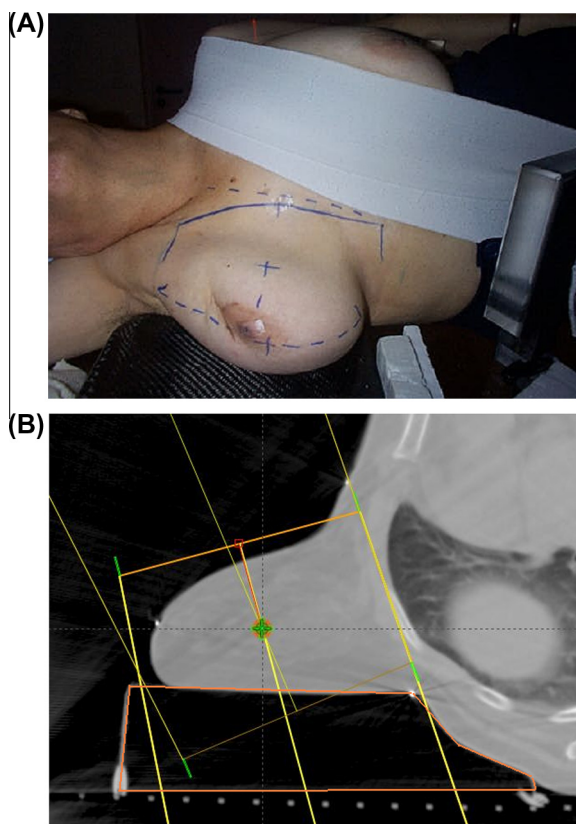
(A) Patient position and immobilization device. (B) The breast lies on the flat part of the breast board. The edge of the angled side is marked by a metallic wire which is visible on CT scan and DRR (arrow).
